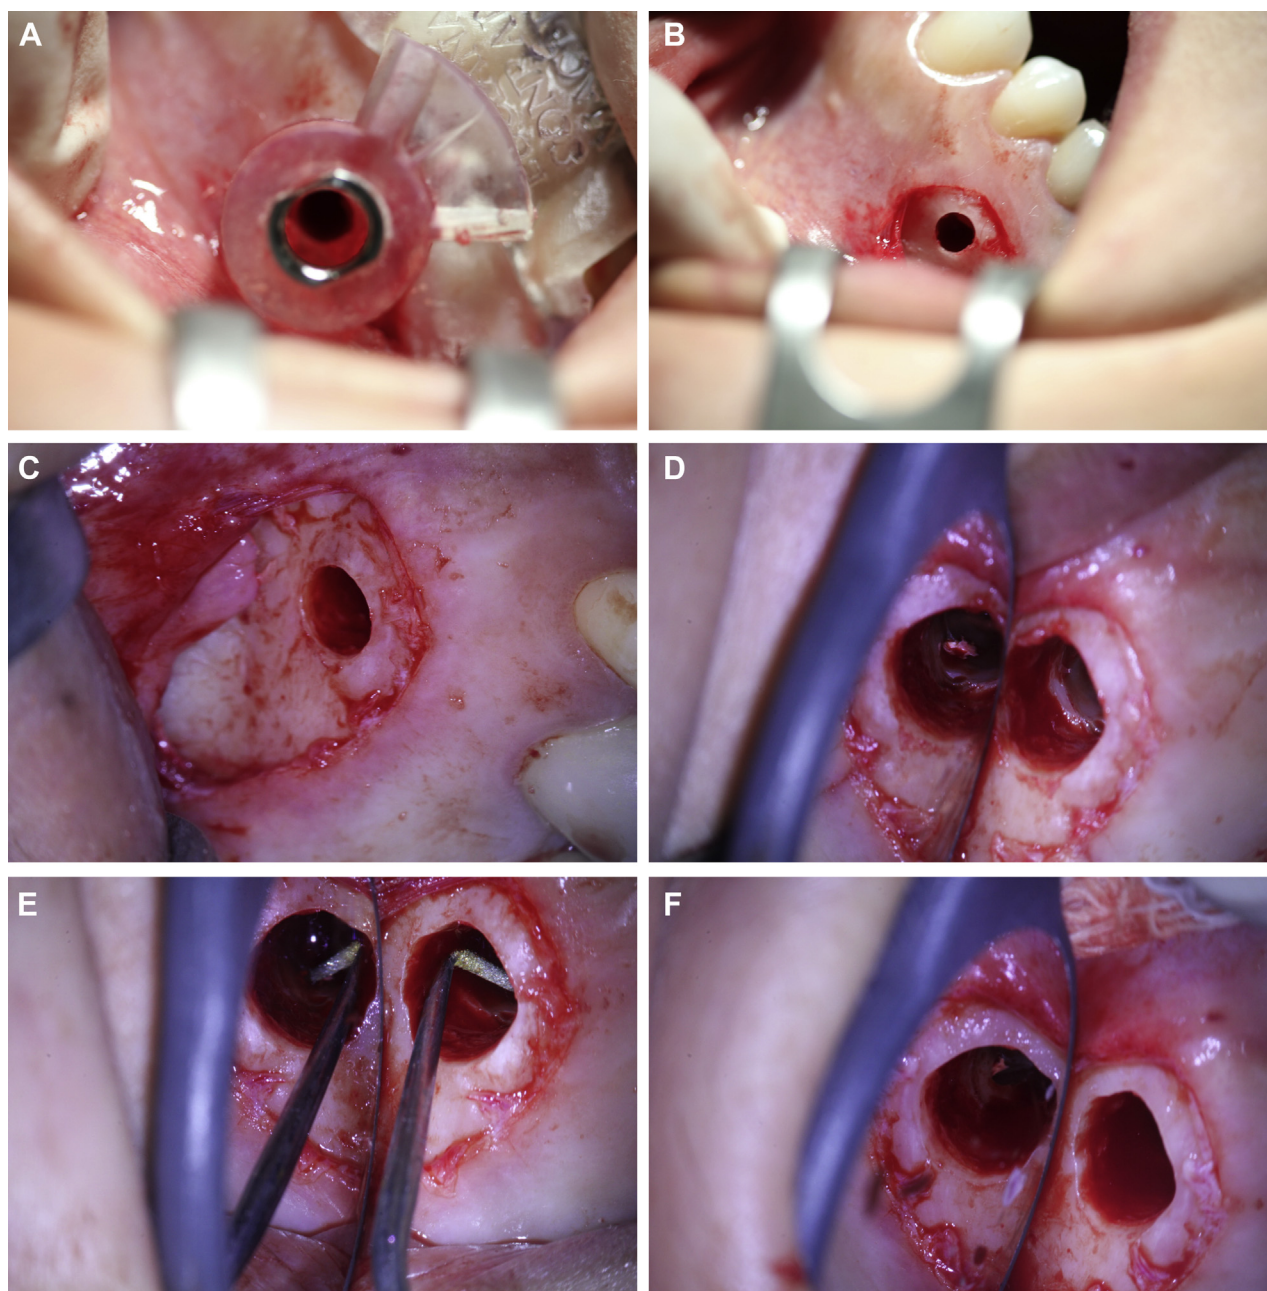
A, View of ultraconservative guided osteotomy. B, Clinical aspect after ultraconservative guided osteotomy and root resection. C, Closer view of clinical aspect after ultraconservative guided osteotomy and root resection. D, Root-end view after root resection. E, Root-end preparation with ultrasonic diamond-tip instrument. F, Clinical aspect after root-end preparation. (Fig 4 continued on next page.)
